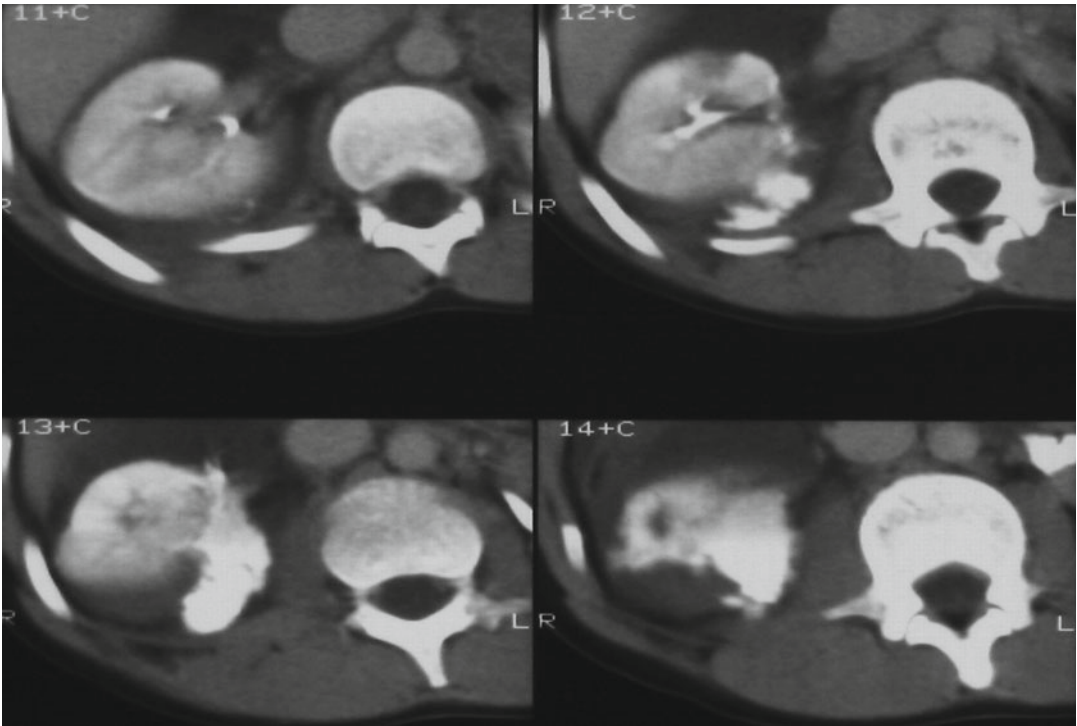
Computed tomography demonstrating right-sided medial contrast extravasation indicative of a renal pelvis laceration (adapted from Wein et al. [3]; with permission)
